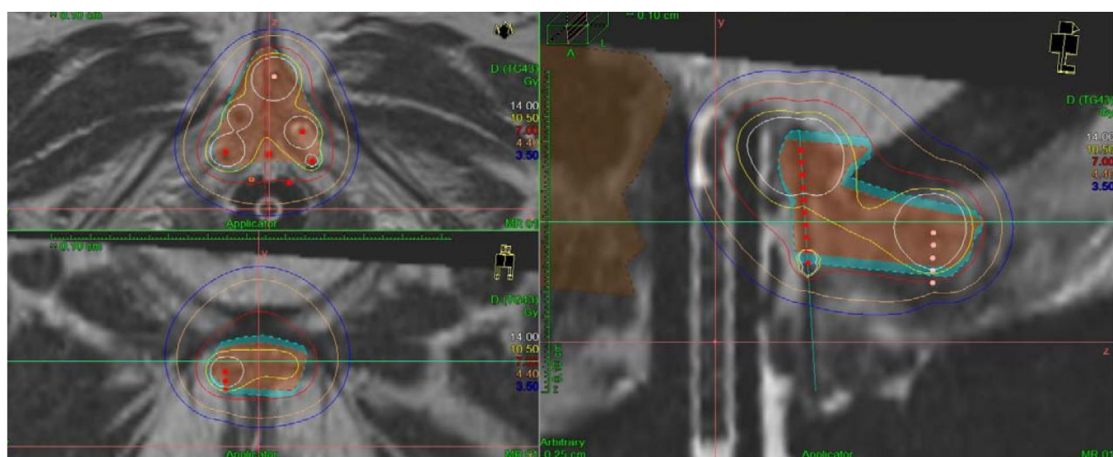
Pelvic magnetic resonance imaging (MRI) scan of margin-positive bladder cancer with catheters and vaginal cylinder in situ with dose distribution (case 4).
